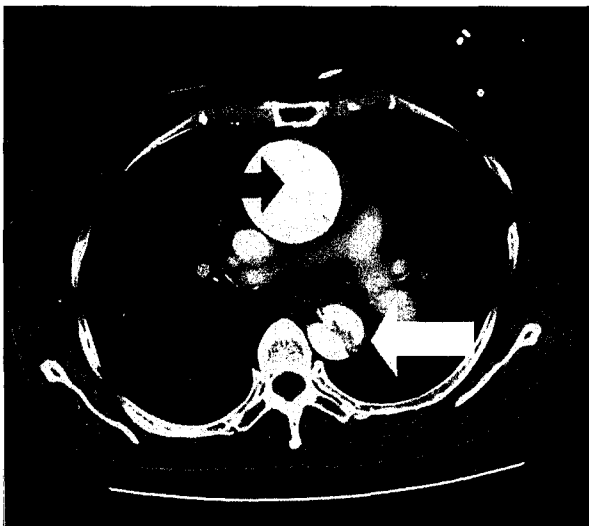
A contrast-enhanced axial CT scan shows an intimal flap in the ascending thoracic aorta (black arrow) and descending thoracic aorta (white arrow). Type I aortic dissection is considered.
